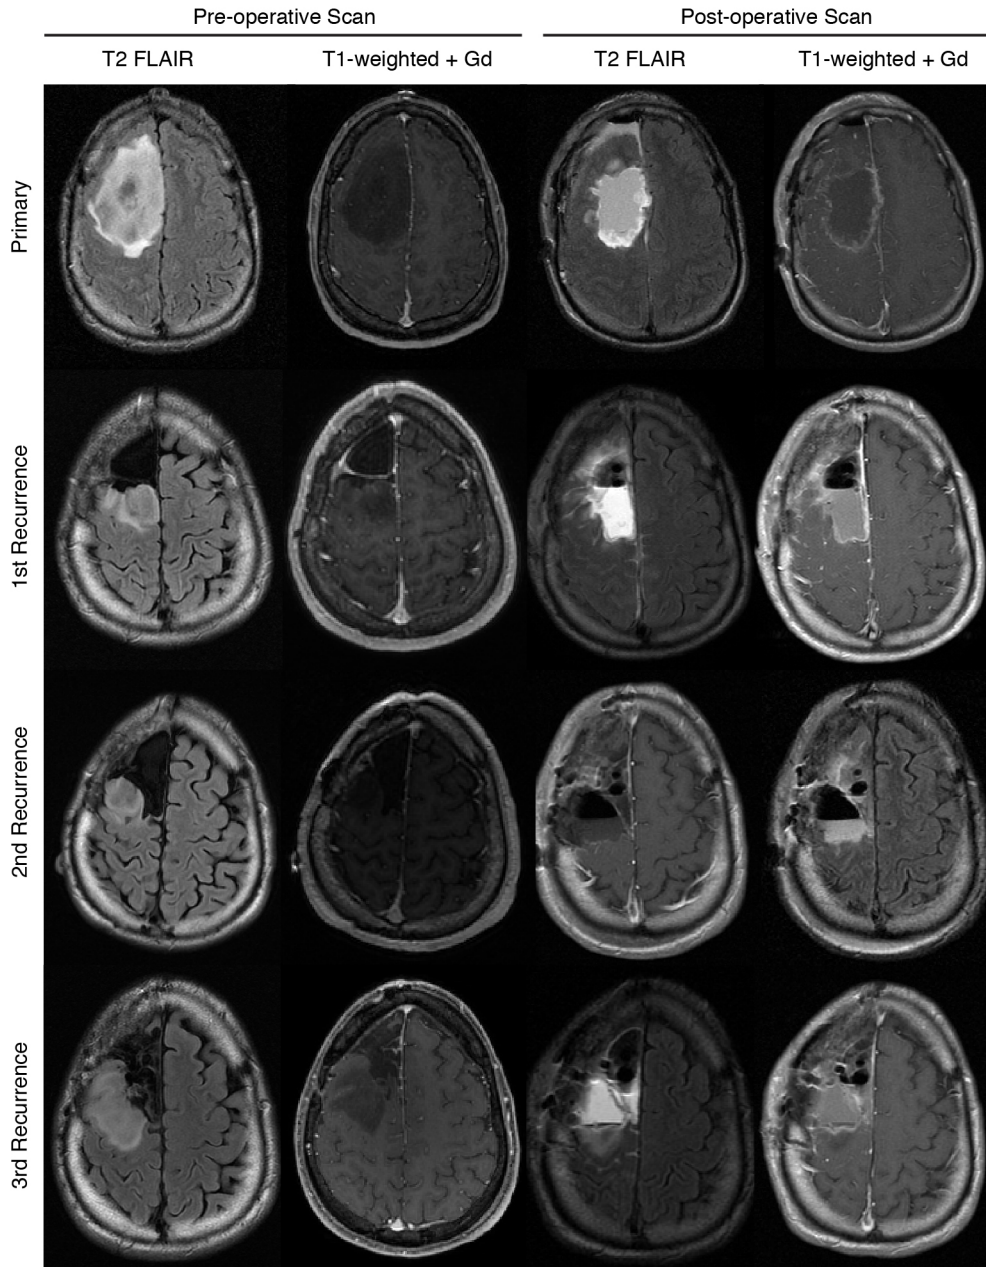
Pre- and post-surgical MR imaging of patient 04. T1- and T2-weighted images representative of the tumor region before and after the initial resection and subsequent three recurrences. Imaging for the initial resection demonstrated a large T2 hyperintense non-enhancing mass situated in the right frontal lobe with significant mass
